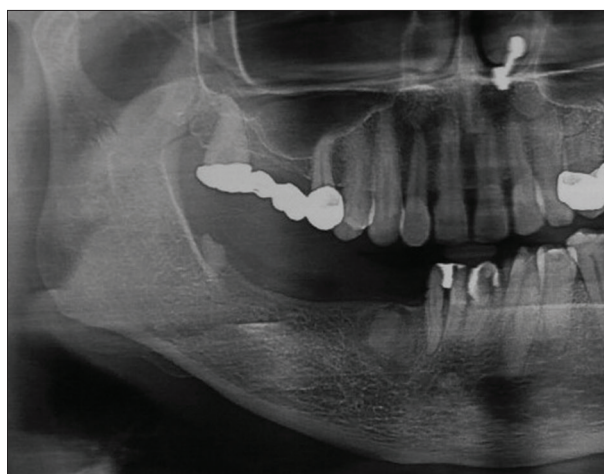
Orthopantomogram of Case no 1 showing missing teeth no 43 to 47
